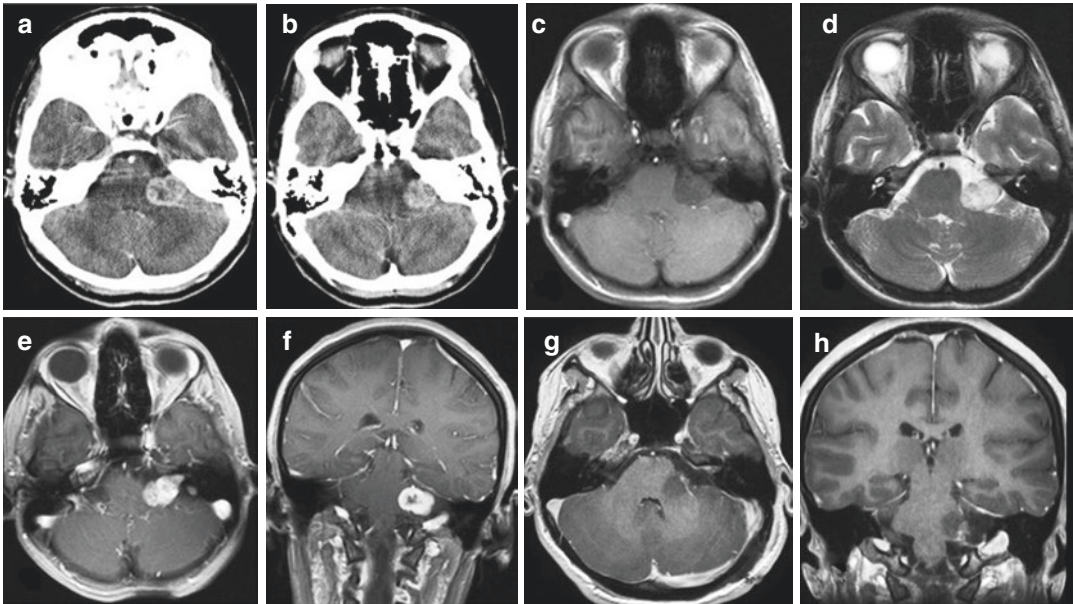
Vestibular schwannoma of left pontocerebellar angle in a 23-year-old woman. The patient presented with numbness in the left face half. Neurological examination showed hypoesthesia in the left face half. Preoperative CT scan demonstrated a tumor in the left pontocerebellar angle (a, b). Preoperative T1- and T2-weighted MRIs (c, d) and T1-weighted axial and coronal MRIs with contrast
